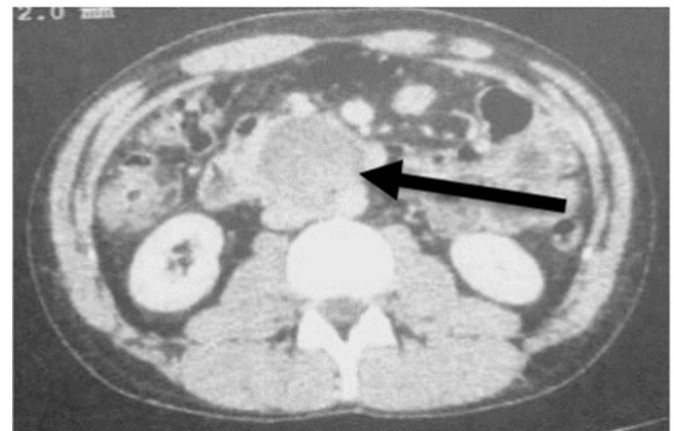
CT (axial slice) after two months of chemotherapy. Reduction of retroperitoneal mass, measuring 5.0 cm in major axis (arrow).
